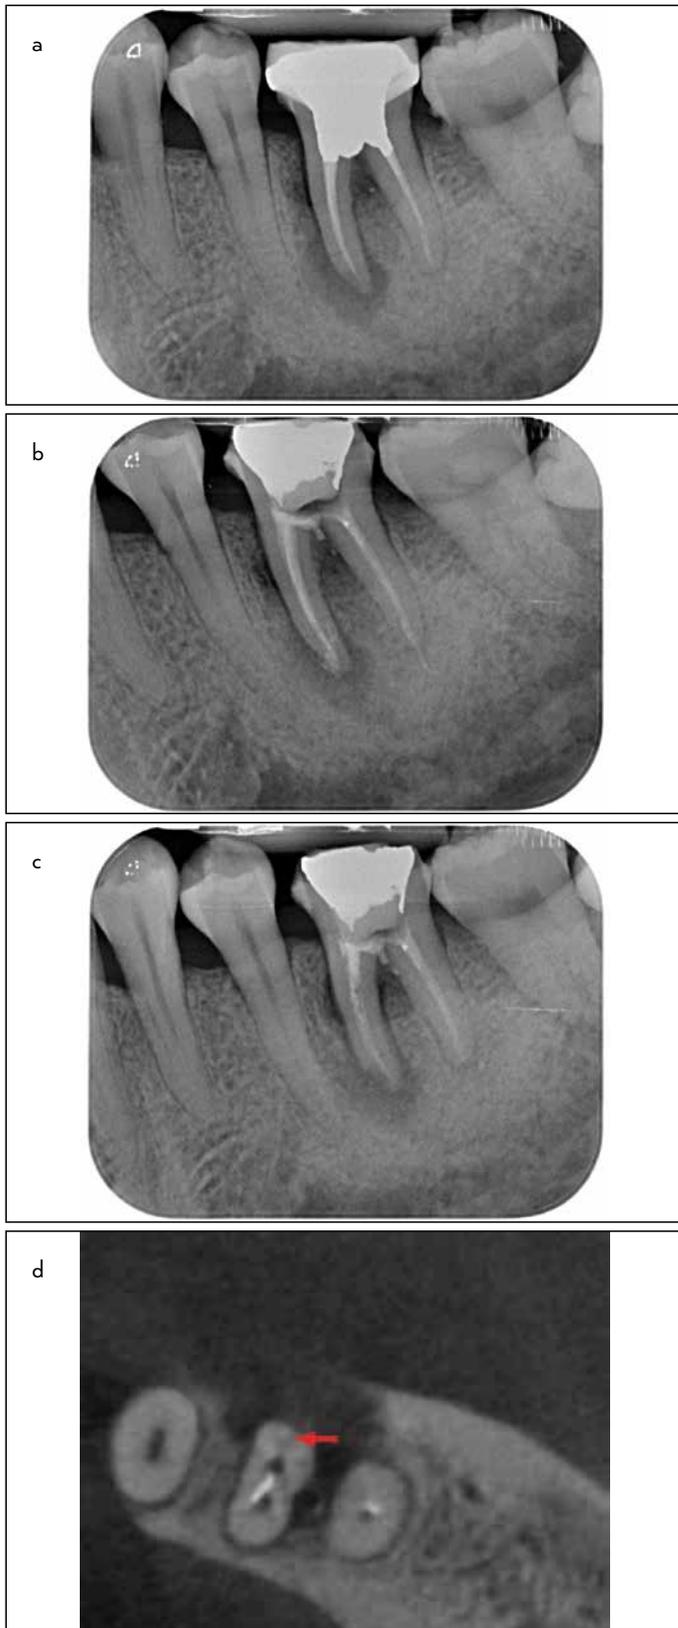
a-d. One case of unresolved clinical presentation after non-surgical exploratory re-treatment. Tooth #36: pre-operative PA radiograph (a); PA radiograph taken immediately after placement of intracanal medication (Calcipex II®). Furcal perforation was repaired with White MTA (ProRoot®, Dentsply, USA) (b); PA radiograph taken 4 weeks after intracanal medication placement: partial disappearance of intracanal medication noted at the middle third of the mesial root (c); and CBCT taken and showing fracture line (arrowed) at the lingual aspect of mesial root (d)
